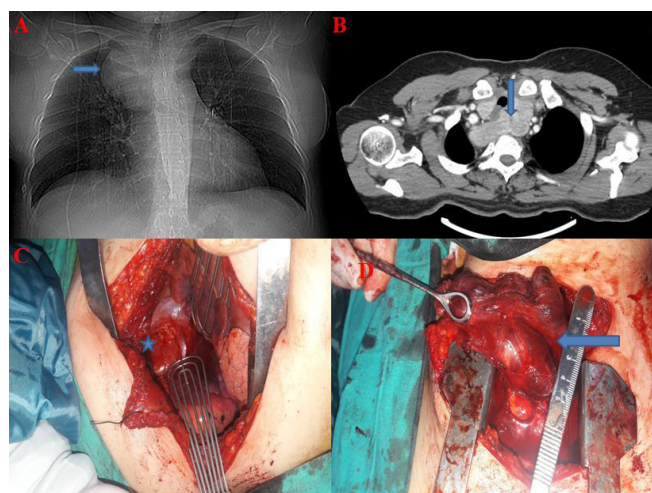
The posteroanterior chest x-ray shows the lesion extending to the upper right mediastinum (a), the computed tomography of the thorax shows the goiter extending from the left cervical region to the right upper mediastinum (b), the image of the goiter released from the mediastinum with right lateral thoracotomy (the star shows the mediastinal mass) (c), the excision of the mass by partial sternotomy (the arrow shows the macroscopic view of the mediastinal mass) (d).
